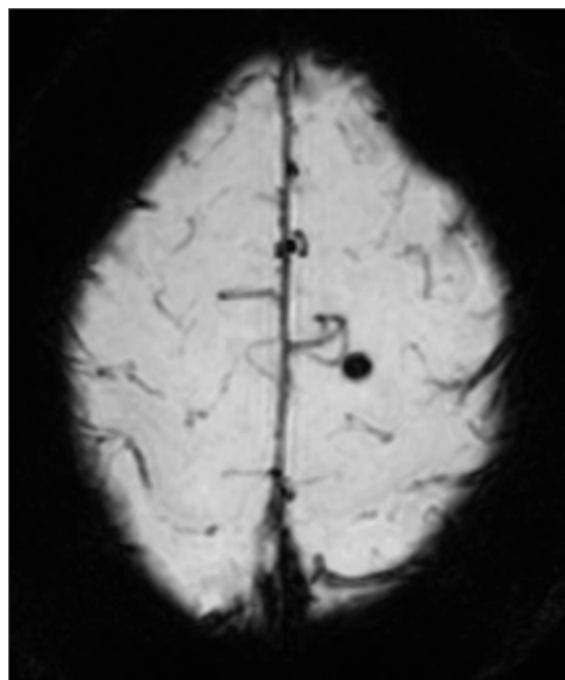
Incidental left frontal cavernoma, without other gross abnormalities, as seen on MRI Brain with and without gadolinium.
